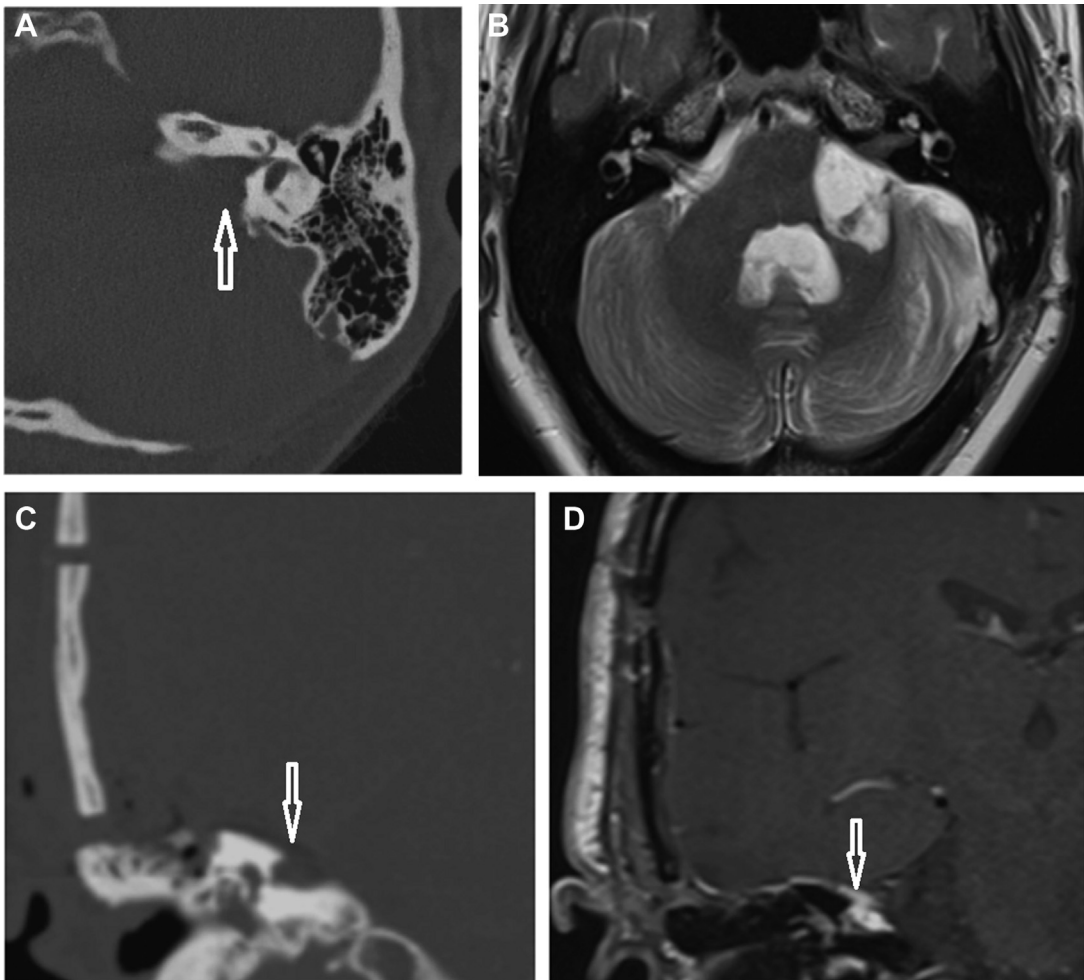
Retrosigmoid and middle cranial fossa approach postsurgical appearances. Post retrosigmoid approach appearances: (A) axial CT demonstrates the expected occipito-mastoid and posterior porus acusticus (*arrow*) bony defects while the (B) T2w axial image reveals left cerebellar encephalomalacic changes and widening of the left CPA. Post-middle cranial fossa approach appearances: (C) Coronal CT demonstrates the temporal craniotomy and defect within the superior IAM (*arrow*) with (D) T1w coronal demonstrating a fat graft at the site of the IAM defect (*arrow*).
